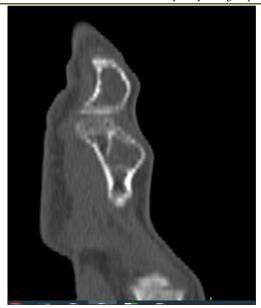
CT scan of left hand sagittal section in bone window: Two osteolytic lesions of left 5th metacarpal and 1st phalanx.
